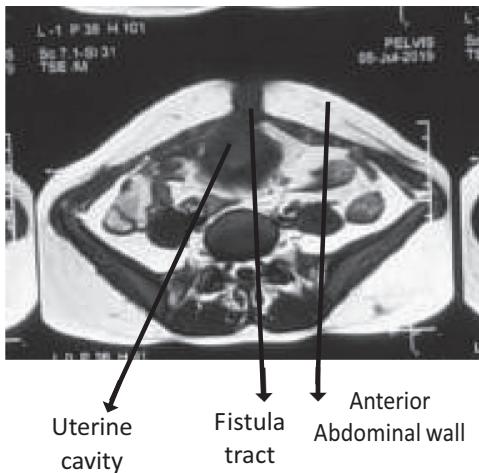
Transverse section of MRI abdomen and pelvis showing fistula tract between uterus and skin.
